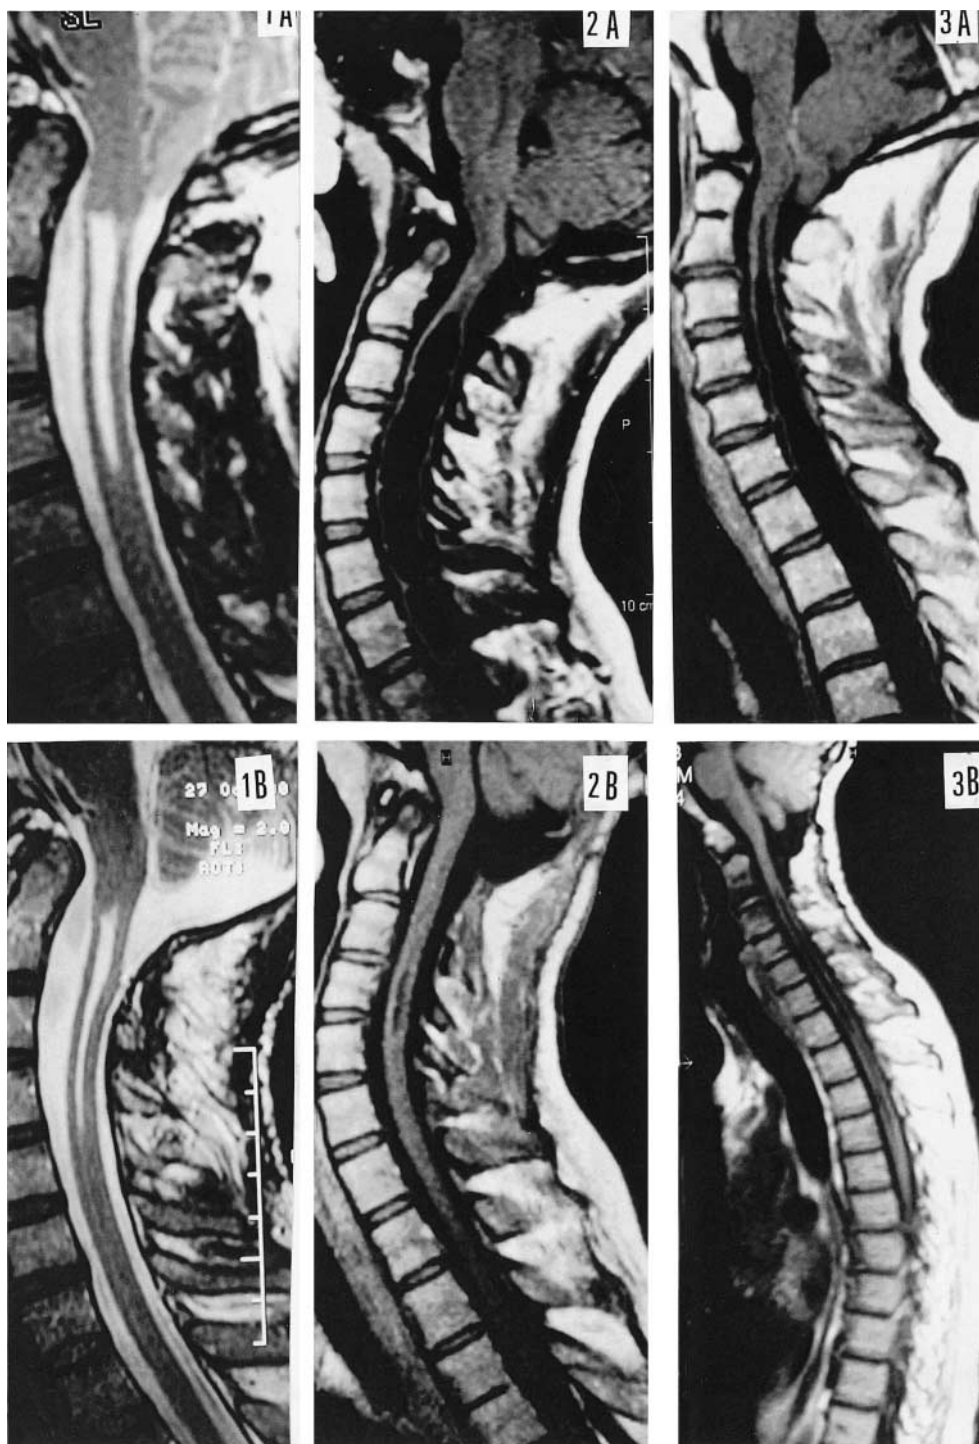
Case N°1*: Chiari I malformation with a cervico-bulbar syrinx before (1A) and 2 years after (1B) Foramen Magnum Decompression. On the post-operative MRI (1B), Cisterna Magna is patent and syrinx has decreased in size [i.e., its anterior – posterior (AP) diameter at the C2–C3 level passed from 55% to 32% of the total AP diameter of the spinal cord]. *Case N°2*: Chiari I malformation with a cervical-thoracic syrinx before (2A) and 6 months after (2B) Foramen Magnum decompression. On the post-operative MRI (2B), Cisterna Magna is patent and the syrinx has mostly disappeared. *Case N°3*: Chiari I malformation with a pan-medullary syringomyelia before (3A) and 9 months after (3B) Foramen Magnum decompression. On the post-operative MRI (3B), Cisterna Magna is patent and syringomyelia has markedly receded (Index of the syrinx decreased from 70% to 30%)
